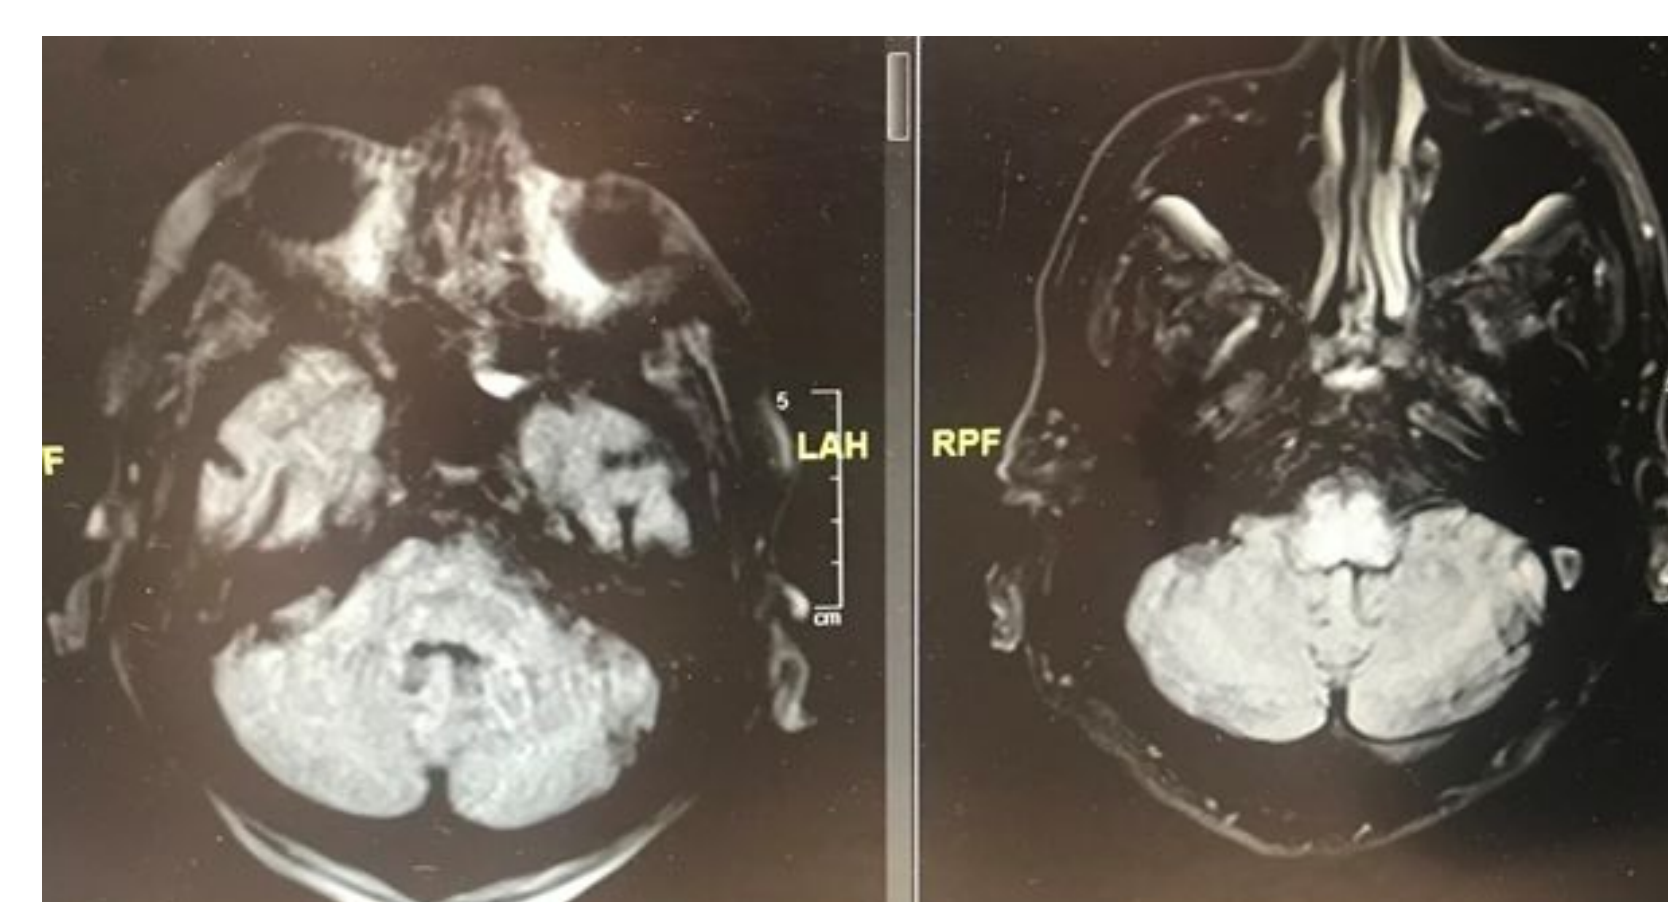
This is a comparison with the axial MRI FLAIR images demonstrating the resolution of the hyperintensity seen in the medulla. Original MRI is seen on the right with later MRI showing improvement on the left.
